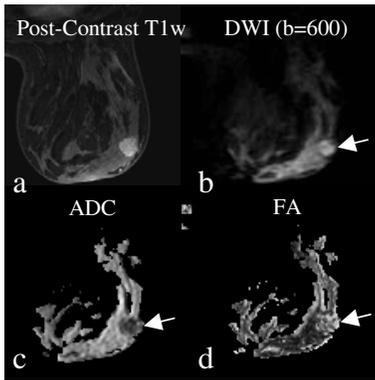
Enhancing invasive lesion identified on post-contrast T1-weighted imaging (a) shows hyperintensity on diffusion-weighted images (b), reduced ADC (c), and increased FA.
